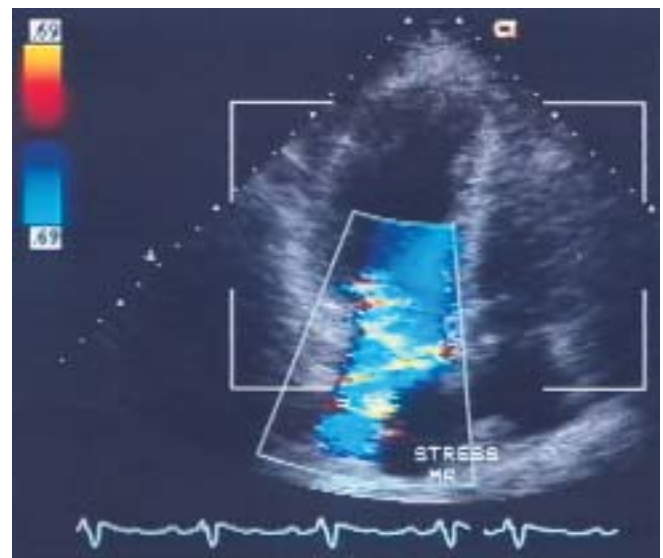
Color flow Doppler image of dramatic increase in MR with exercise.
